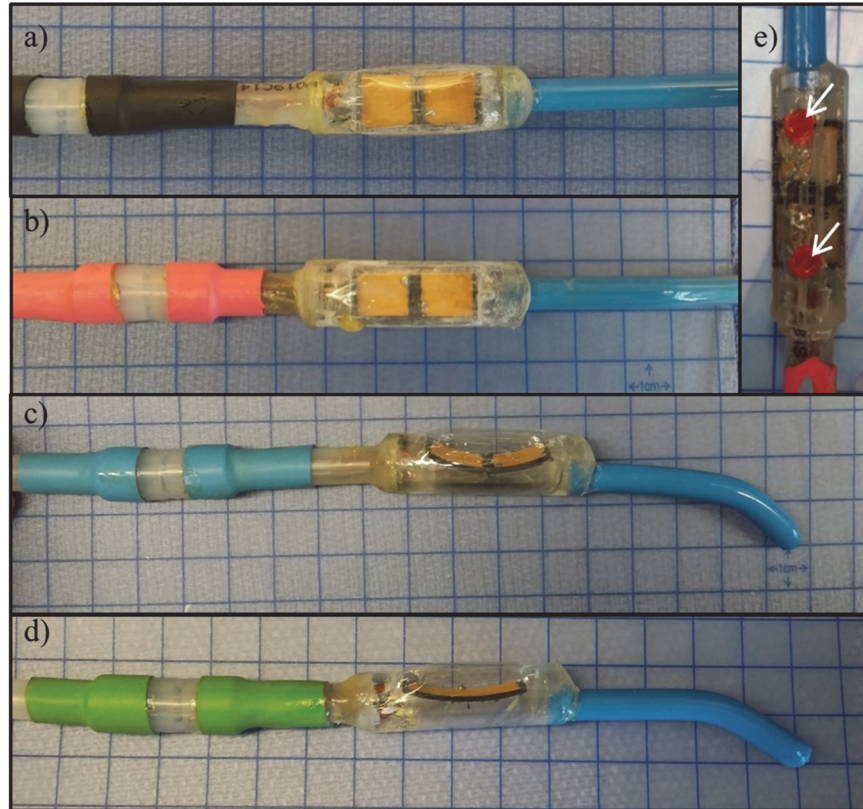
Fabricated (a) dual planar, (b) dual lightly-focused curvilinear, (c) dual strongly-focused curvilinear, and (d) single strongly-focused curvilinear endoluminal ultrasound applicators. (e) Two spiral tracking coils (arrows) for active MR tracking were integrated on the backside of each transducer assembly fixture.
